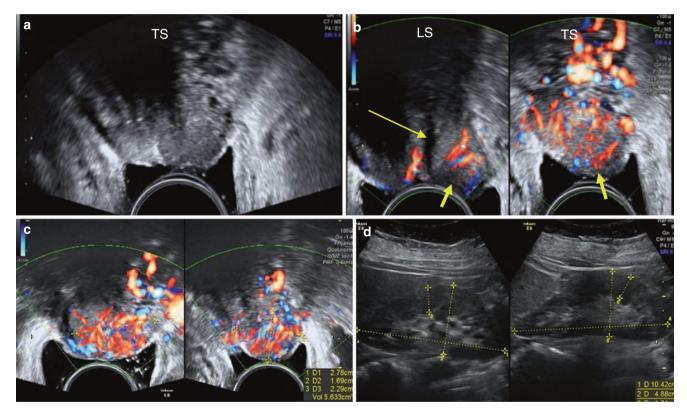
Case of squamous cell carcinoma of cervix Stage III. Scan was done to assess tumour size after six doses of RT. (a) Small hypoechoic lesion is seen in the anterior lip of the cervix. (b) Cervical canal (*long arrow*) seen. Flow seen in tumour mass (*short arrows*). (c) Extent of the mass is seen better with Doppler. (d) Normal kidneys, with no evidence of hydronephrosis
